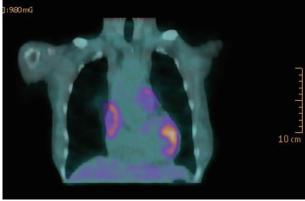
The CT of chest (upper panel) showed 3 lobular lesions over pericardial area; and the PET scan (lower panel) showed enhance uptake in anterior mediastinum and pericardium area.
